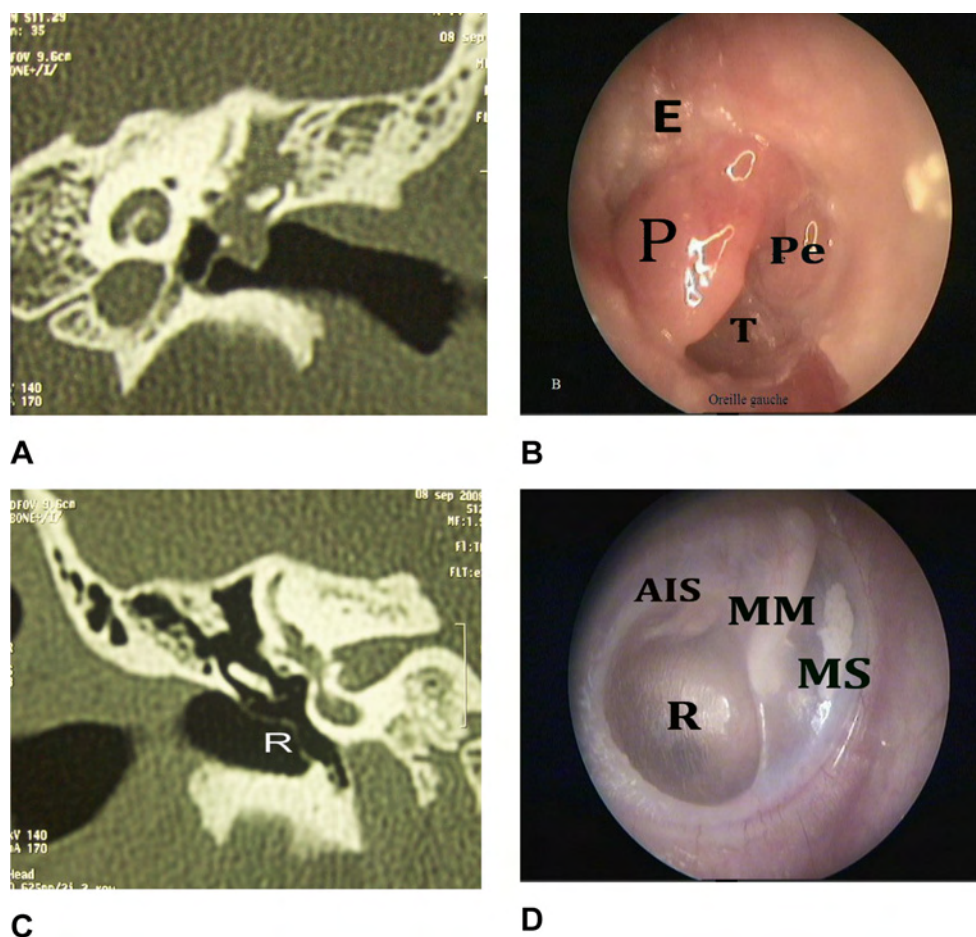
Polyp of the external auditory canal of a left ear. A. Coronal cut of CT scan of the left ear, lysis of the descending branch of the uncus with prolapsing aspect of tissue mass through the tympanic membrane into the lumen of the external acoustic meatus. Note the denudation of the tympanic portion of facial canal and that of the lateral semicircular canal. B. Oto-endoscopic aspect with rigid optic 0, showing the polyp at the bottom of the external acoustic meatus. C. Coronal cut of CT scan of the right ear, in the same child. Integrity of the ossicular chain, good ventilation of the middle ear cavities. Note the invagination of the pars tensa which is visible on clinical examination. D. Oto-endoscopic aspect with rigid optic 0, showing the poster superior retraction of the pars tensa which remains controllable and self-cleaning. E. Part of the cupular epitympanum. P: Polyp; T: Eardrum; Pe: Perforation of the posterior superior part of the pars tensa; MAE: External acoustic meatus; CSCL: lateral semicircular canal; CT: computed tomography; AIS: incudostapedial joint; R: Retraction; MS: myringosclerosis; MM: Handle of malleus.
